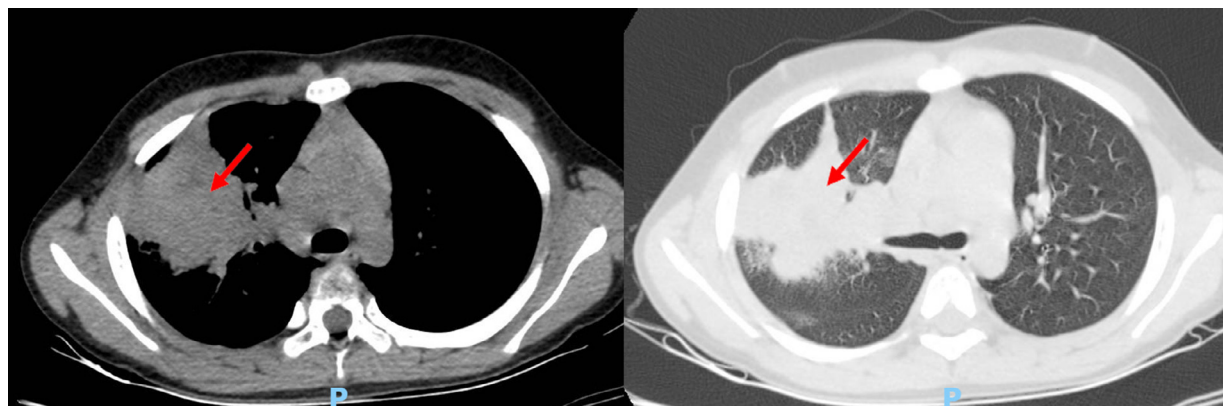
Chest CT scan revealed a $31 \times 28 \text{ mm}$ consolidation (arrow), as well as a right pleural effusion and surrounding ground-glass opacity in the upper edge of the right lung hilum
